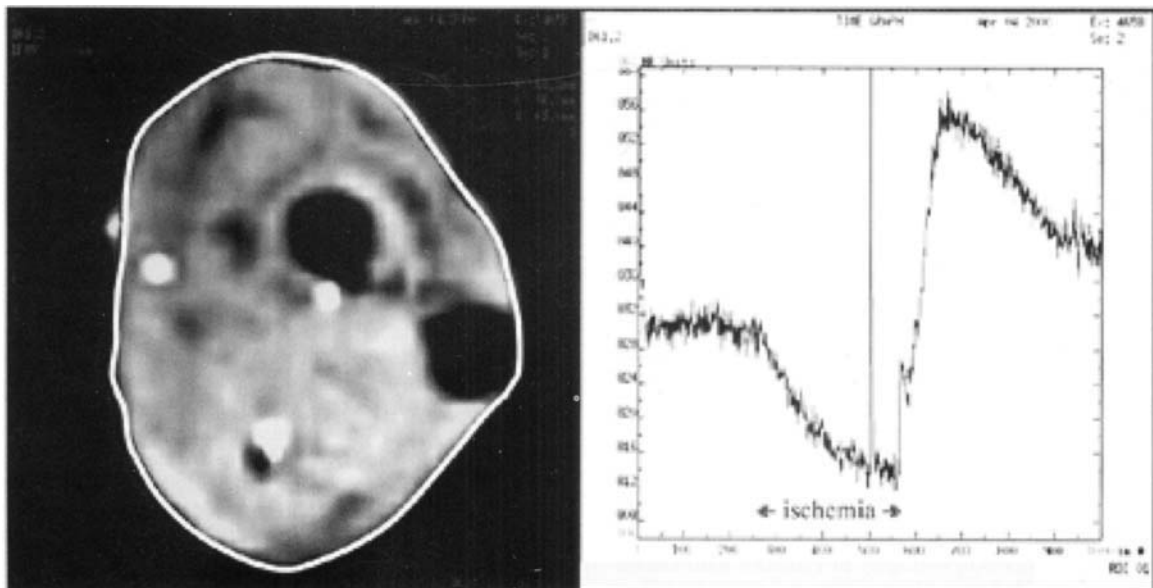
BOLD-MRI signal in a healthy volunteer. Left panel: Cross-sectional BOLD-MRI view of the right forearm 10cm below the elbow joint. The white line depicts the region of signal intensity measurement. Right panel: Time to signal intensity curve before, during and after 3 minutes of cessation of blood flow. The signal decrease during and the signal overshoot after cuff-induced ischemia is demonstrated. The narrow peak after 500 images represents the start of the second image series.
